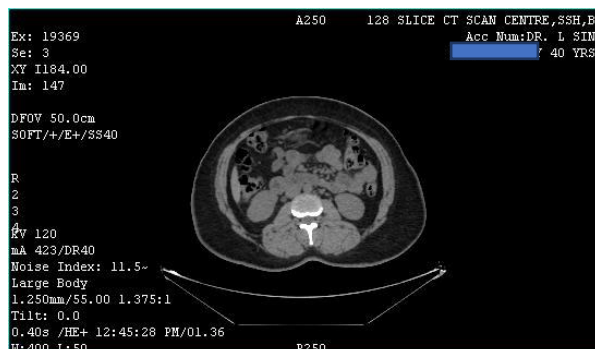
Axial CT (After Treatment)- showing normal axial view of lower pole of right kidney (previous calculus of 2.2mm not seen)
